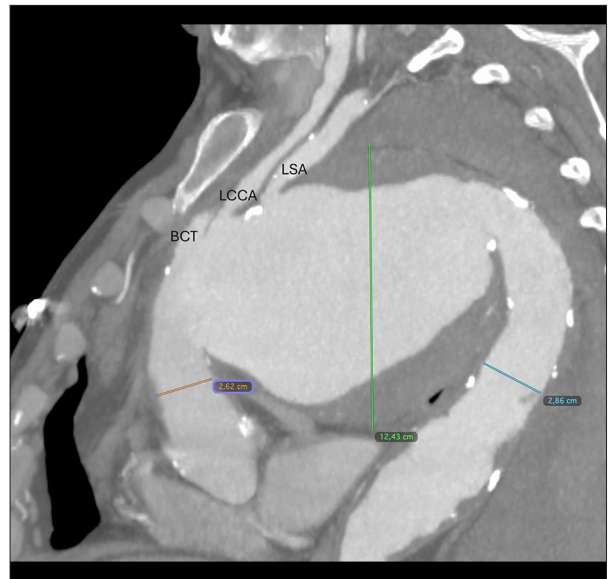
Computed tomography showing 3 vessels departing from the ruptured aneurysm: brachiocephalic trunk (BCT), left common carotid artery (LCCA) and left subclavian artery (LSA). Measured dimensions of the aortic segments: ascending aorta (orange mark), aneurysmal ascending aorta (green mark), and descending aorta below the aneurysm (blue mark).
